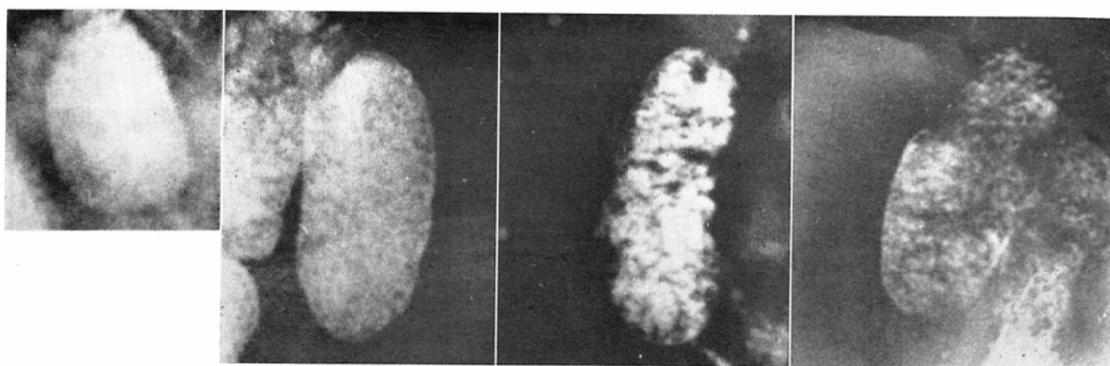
Standard roentgenograms for foamy appearance. From left to right: Grade 0 (normal), Grade I (slight), Grade II (moderate), and Grade III (marked).
